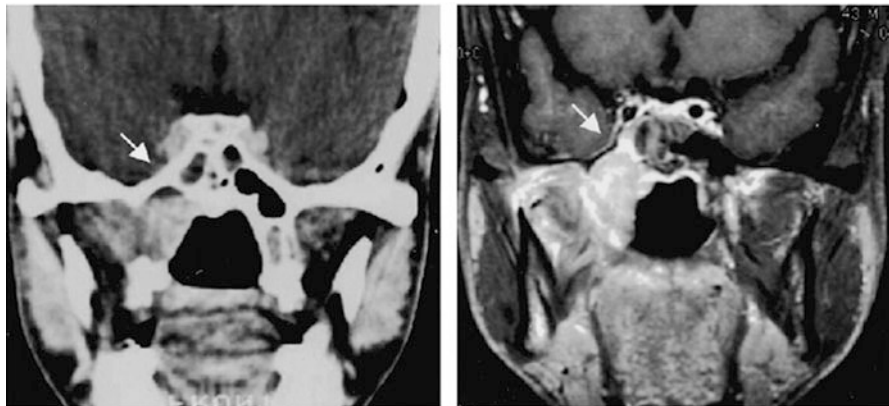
Extension into right cavernous sinus is shown by T1 contrast enhanced MRI (*right*) but not appreciated on CT (*left*) [34]
